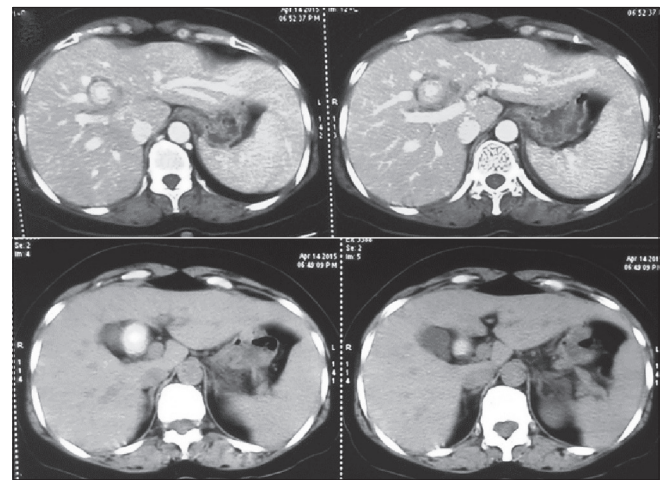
Contrast-enhanced computed tomography abdomen showing calculi
